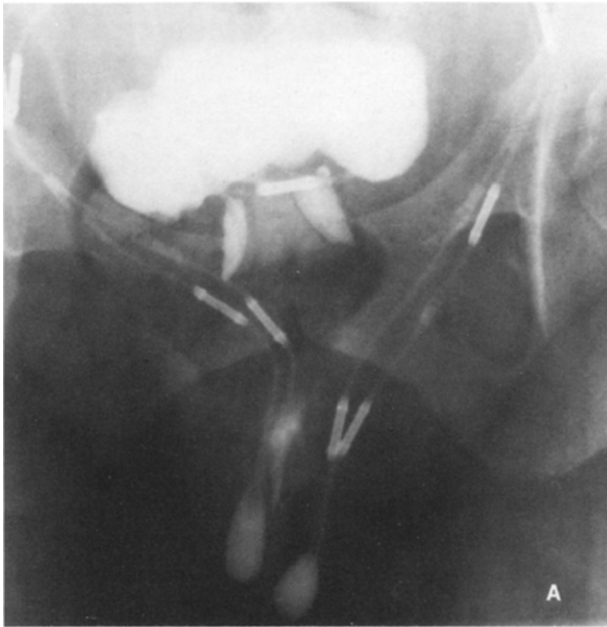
Case 1. Fluorocystography showing no leakage on coughing or straining while bladder contained 300 cc. radiopaque fluid, and (B) radiopaque fluid in prosthetic sphincter allows periodic radiographic evaluation.
